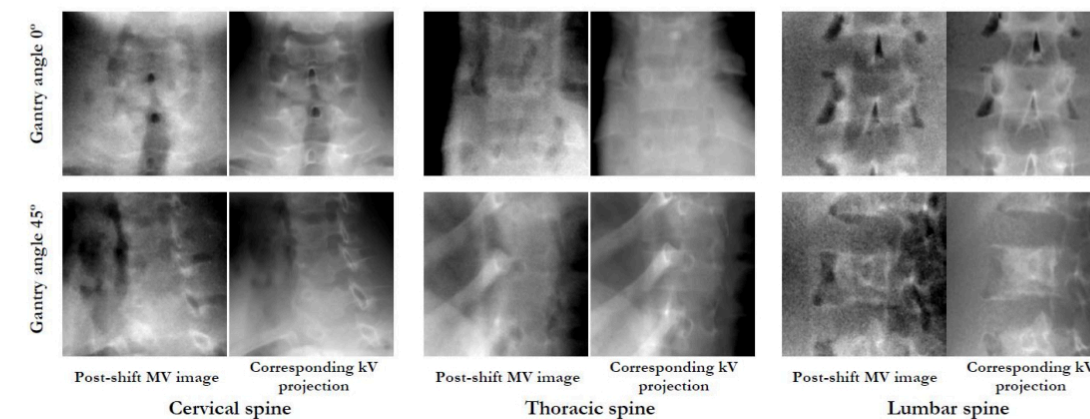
Examples of MV image and corresponding kV projection image of pre-shift CBCT (not co-registered). The following image processing steps were performed before image registration: 1) center correction for both MV/kV; 2) edge preserving filtering to reduce image noise, contrast-limited adaptive histogram equalization (CLAHE) to MV image to enhance contrast; 3) histogram adjustment of MV image to match histogram of corresponding kV projection.
